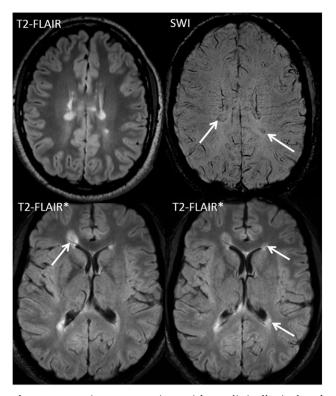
Patient presenting with a clinically isolated syndrome. Brain MR imaging shows typical demyelinating lesions of the type seen in multiple sclerosis, involving the periventricular white matter. Observe the presence of hypointense rims in multiple of these lesions likely reflecting iron deposition, on the susceptibility-weighted images (SWI) (arrows), and of central veins on T2-FLAIR* images (arrows).
